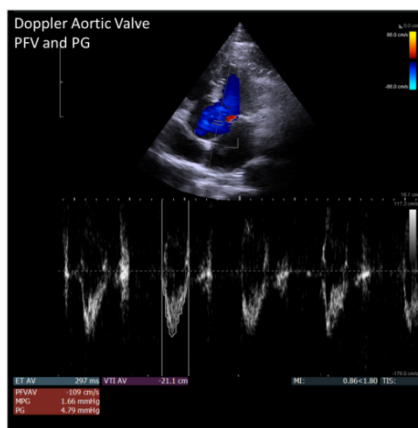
Doppler Aortic Valve PFV and PG measurements.
